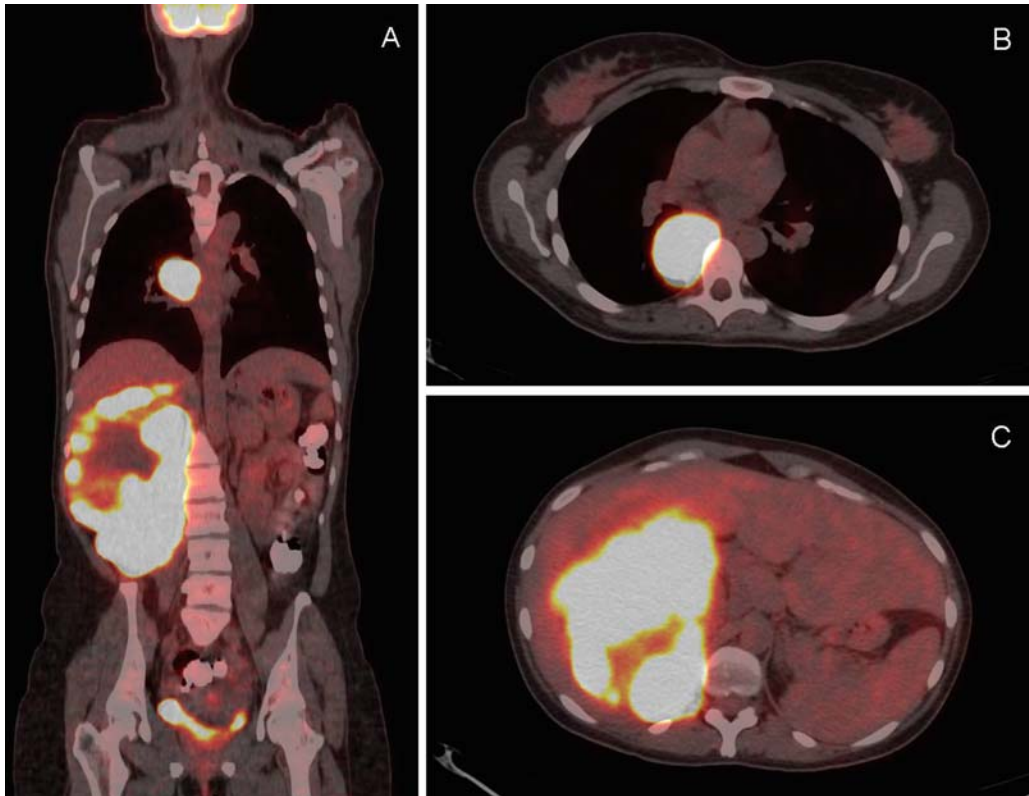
FDG PET/CT images of a young woman with metastatic recurrent right adrenal cortical carcinoma. Study requested for restaging of disease. (A) Coronal view of the PET/CT scan, which shows the large and metabolically very active recurrent tumor in the right adrenal bed of 16.5×12.3 cm (SUV = 43.6), and the metastatic lesion to the posterior mediastinum (SUV = 40.3). (B and C) Axial images of the PET/CT scan at the level of the chest and upper abdomen, respectively, demonstrating the tumor lesions.
